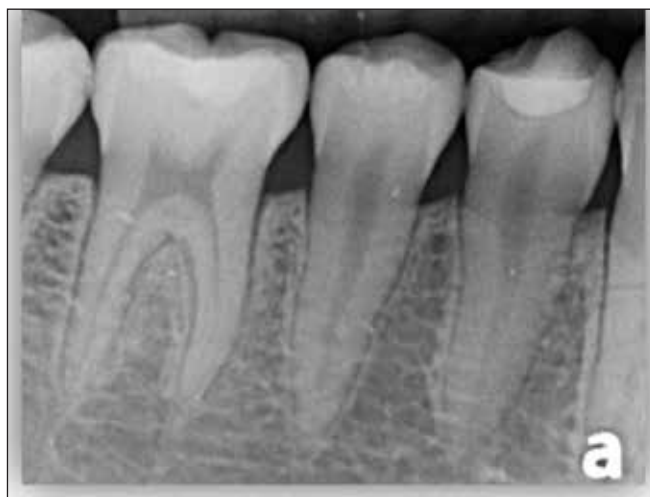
One year follow up periapical radiograph of #35 showed normal periodontal ligament space, surrounding bone trabeculation and periapical area.
